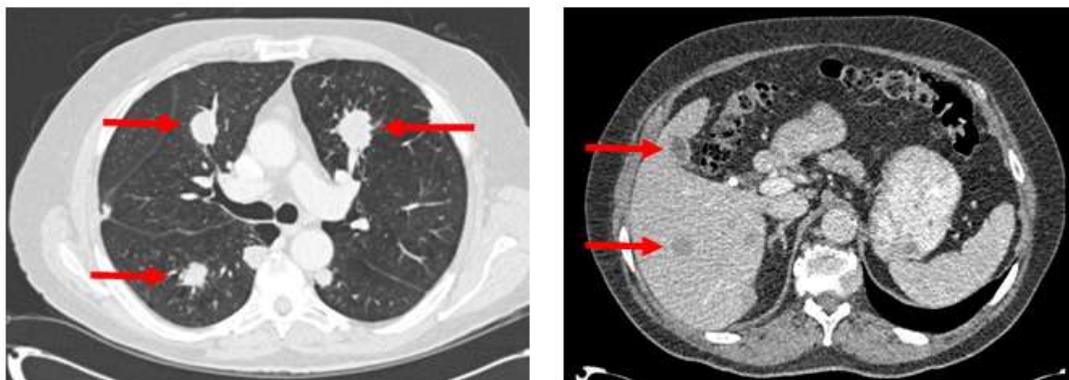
Metastatic disease prior to commencing chemotherapy. Left: CT chest (axial) showing multiple pulmonary metastases (red arrows). Right: CT abdomen (axial) showing multiple hepatic metastases (red arrows).
